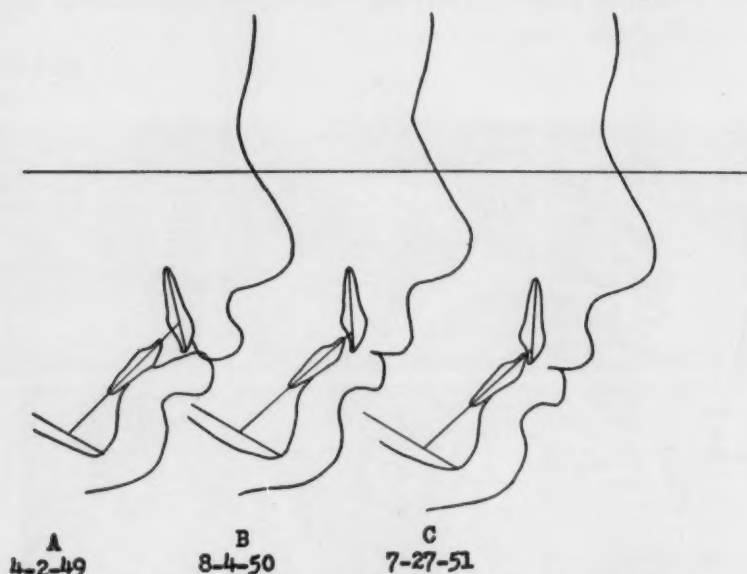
Case 3, Patient S. L. Profile study made from cephalometric roentgenograms. A, Before treatment; B, after treatment; C, postretention.
